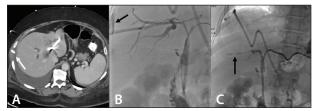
Transhepatic parenchymal tract embolization. CT demonstrated inadvertent transgression of the pleura by the right biliary drain (white arrow) (A). A pullback sheath cholangiogram demonstrated contrast spilling into the pleural space (black arrow) (B). A single 5–7-mm Caterpillar plug was placed across the transhepatic tract to ensure no further biliary leakage into the pleural space (black arrow) (C).
